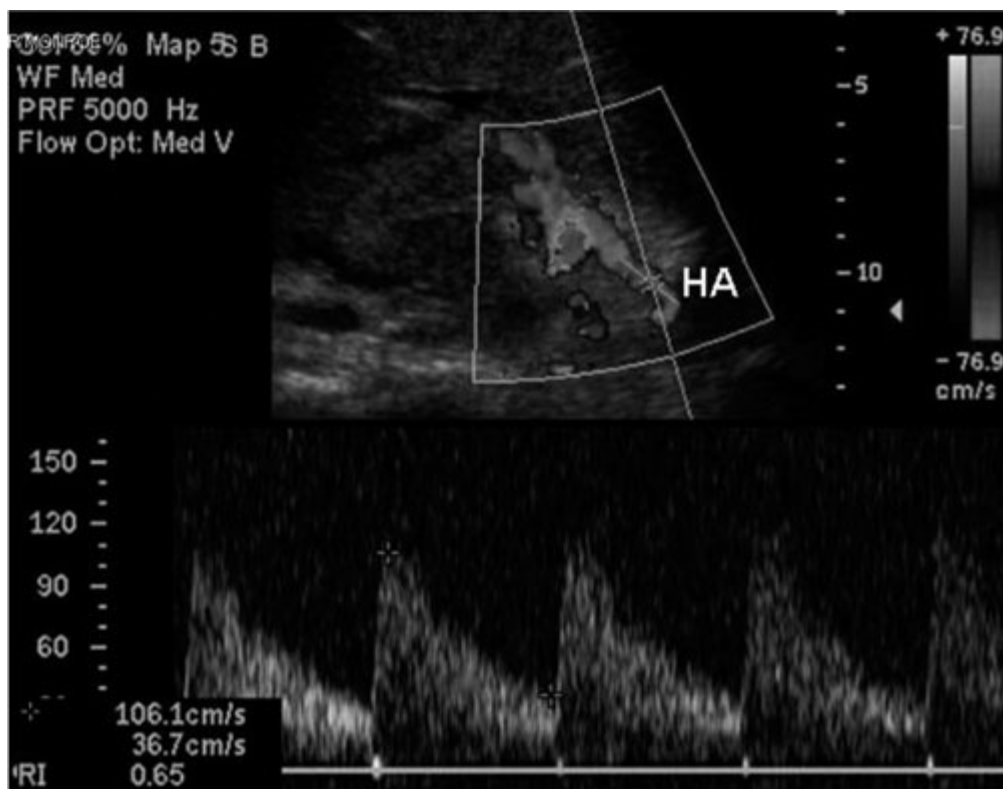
Doppler signal of the hepatic artery (HA). (Color image provided online.)
